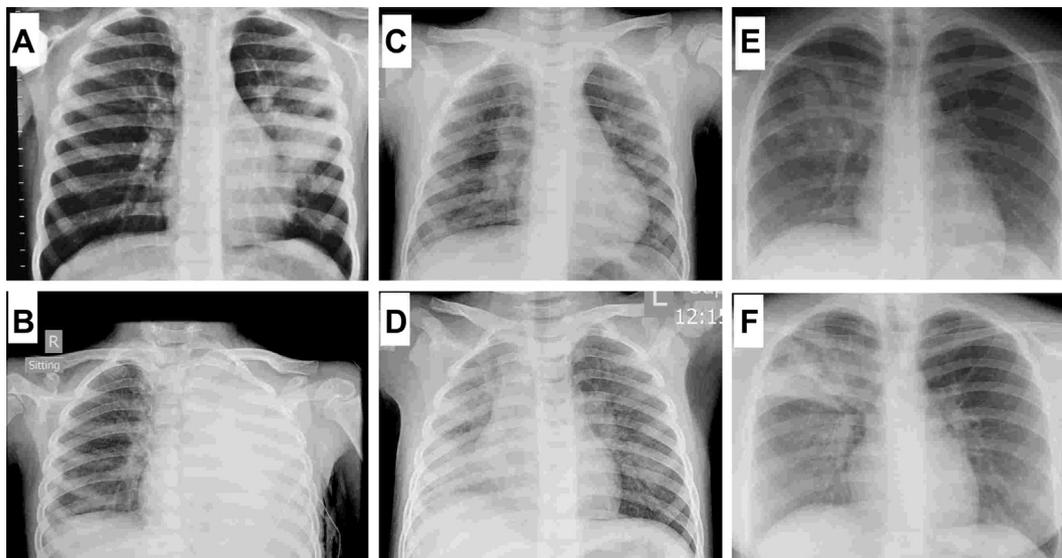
Radiological findings in three hospitalized children with MRMP pneumonia and disease progression after macrolide failure. (A) Patient 1, chest radiograph taken on Day 4 after onset, showing left middle zone consolidation. (B) Patient 1, chest radiograph taken on Day 13 after onset, showing progression of consolidation changes and left side empyema. (C) Patient 2, chest radiograph taken on Day 7 after onset, showing bilateral interstitial infiltrates. (D) Patient 2, chest radiograph taken on Day 12 after onset, showing progression with consolidation changes in right lung and pleural effusion. (E) Patient 3, chest radiograph taken on Day 7 after onset, showing consolidation changes in right upper zone. (F) Patient 3, chest radiograph taken on Day 10 after onset, showing progression of consolidation changes in right lung. MRMP = macrolide-resistant *Mycoplasma pneumoniae* pneumonia.
